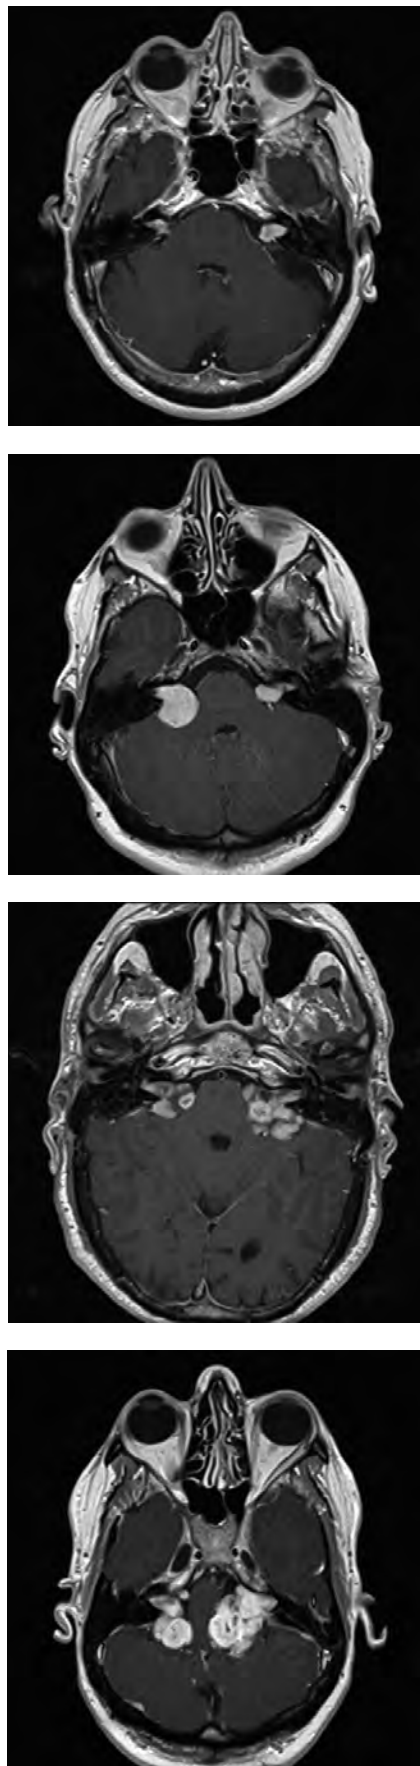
A series of T1 weighted axial MRI scans with gadolinium from 4 NF2 patients with bilateral vestibular schwannomas of varying size and nature. Ranging from almost completely intracanalicular (1a Top) to large multi-lobulated schwannomas with significant brainstem compression (1d bottom).
